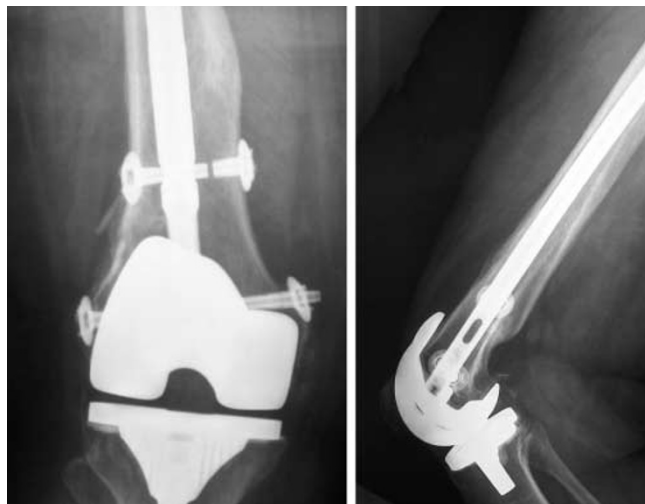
Radiographs 12 months after fixation of a periprosthetic fracture of the distal femur using a longer nail and condylar bolts for distal locking showing solid fracture union
